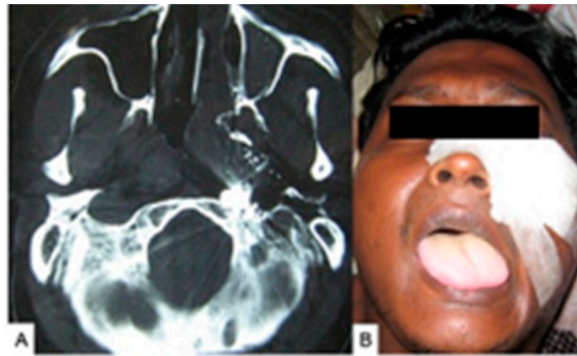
(A) CT scan of the head (axial view) (bony window) showing bullet fragments near the left hypoglossal canal that entered through the face. (B) Picture of a patient with left hypoglossal palsy. Source: Figure by authors.
